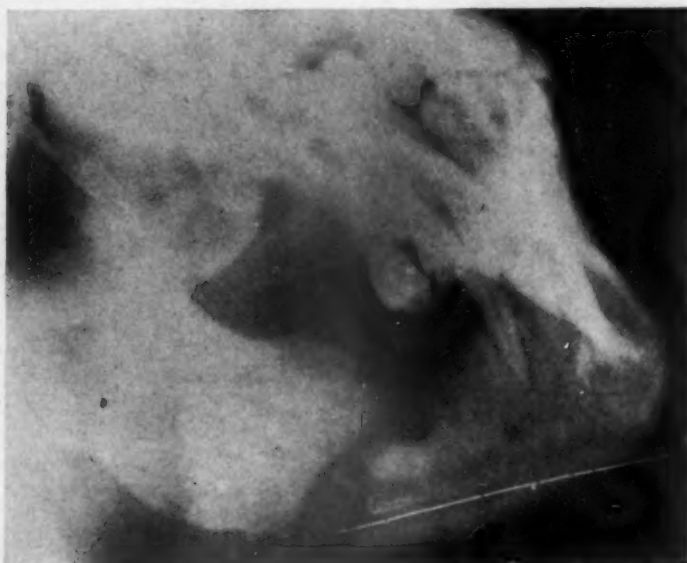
Lateral x-ray showing ununited mandibular fracture.
